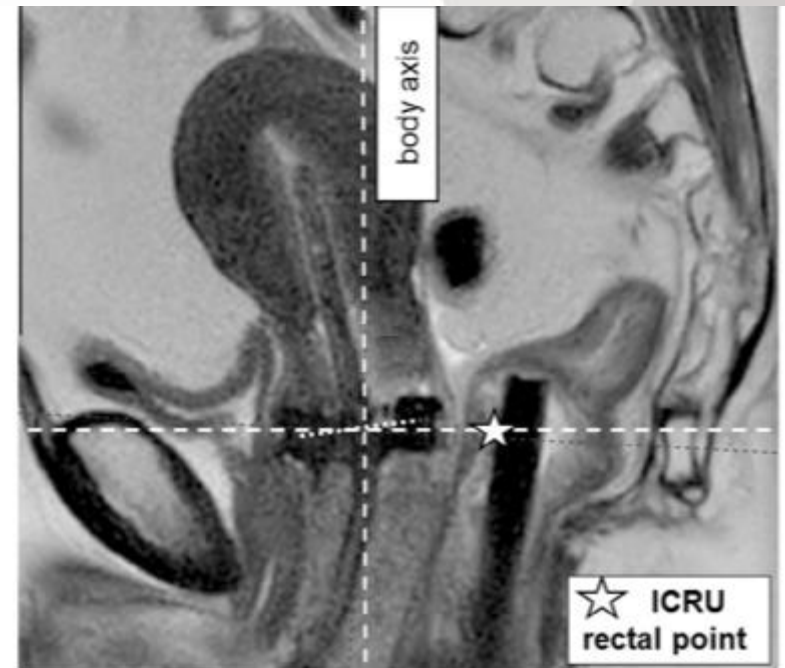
ICRU rectal point depicted on sagittal T2 MRI, positioned at the intersection level between tandem and the source positions in the ring and 5 mm dorsal of the posterior vaginal wall on the axis perpendicular to the body axis.
